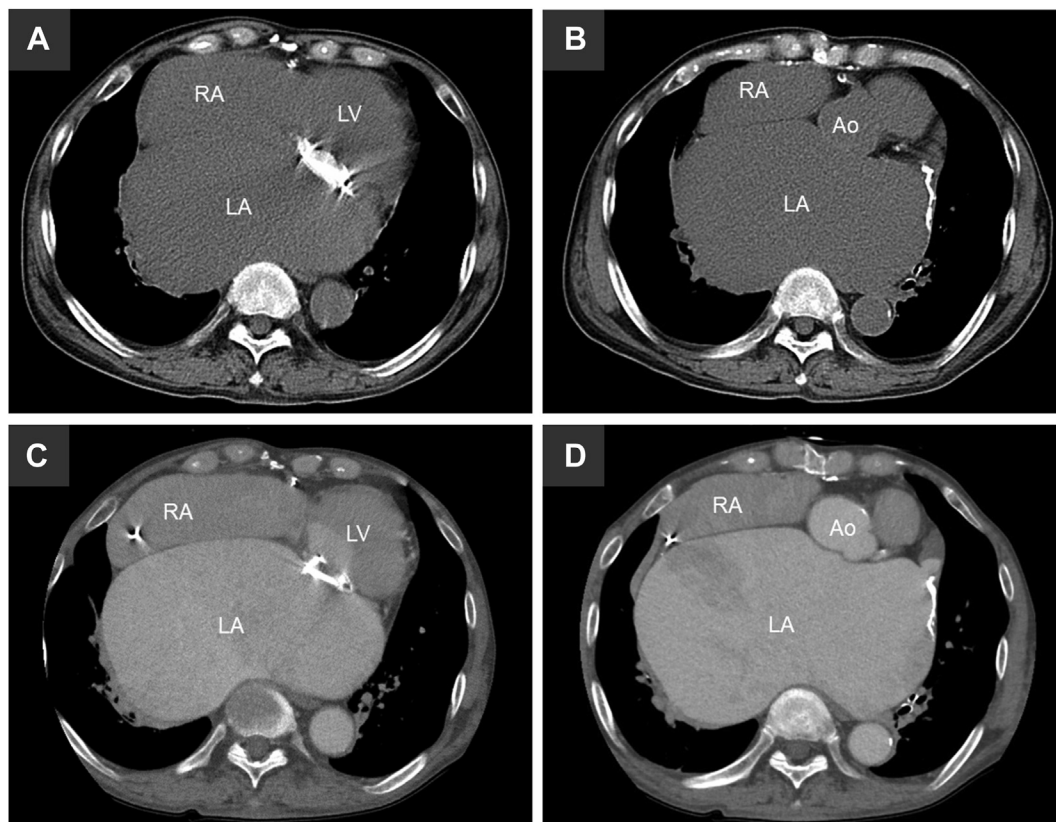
(A, B) Plain computed tomography (CT) 7 years earlier and (C, D) contrast-enhanced computed tomography on admission. Ao, aorta; LA, left atrium; LV, left ventricle; RA, right atrium.
